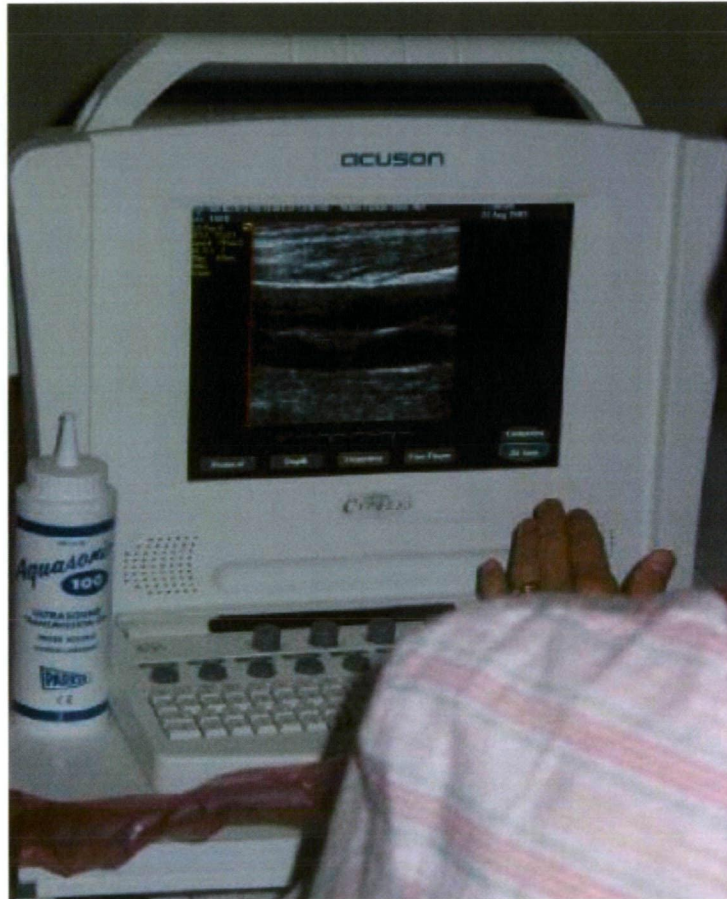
Acuson Cypress portable ultrasound machine
